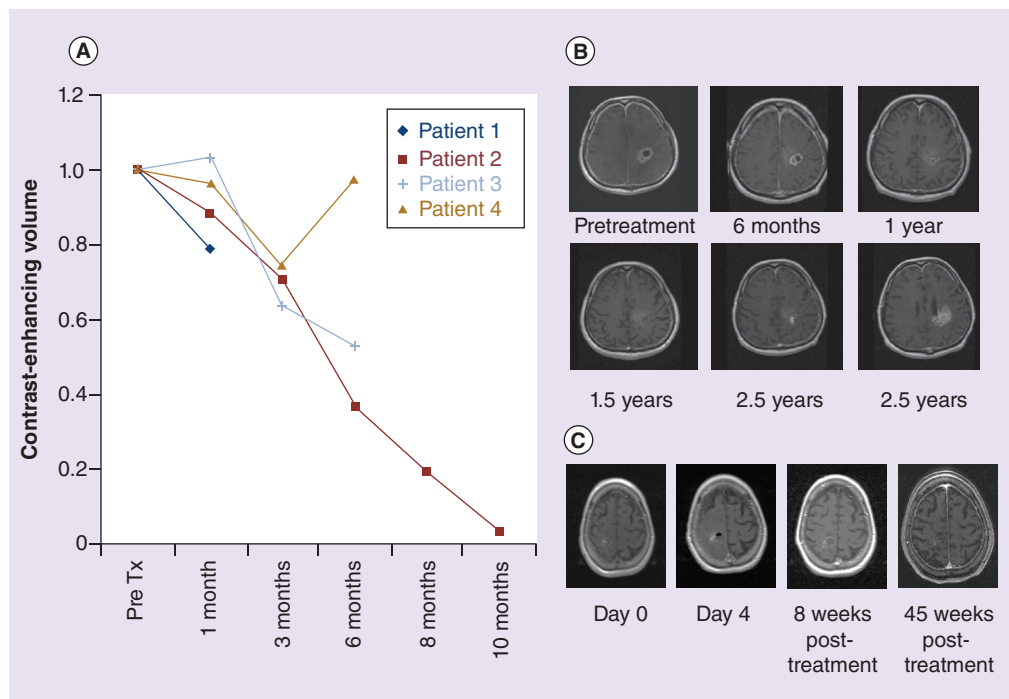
Dose escalation clinical trial of convection-enhanced delivery with topotecan. (A) Early responders: four of 16 patients treated with convection-enhanced delivery of topotecan for recurrent glioblastoma demonstrated a dramatic response, shown here as contrast-enhancing volume plotted over time. (B) Serial MRI (T1 + gadolinium) from the patient with the greatest response demonstrates near complete resolution of enhancing tumor at 1.5 years post-convection-enhanced delivery, prior to eventual disease recurrence at 2.5 years post-treatment. (C) Serial MRI (T1 + gadolinium) from a patient with response and no MRI evidence of recurrence at 45 weeks post-treatment.
